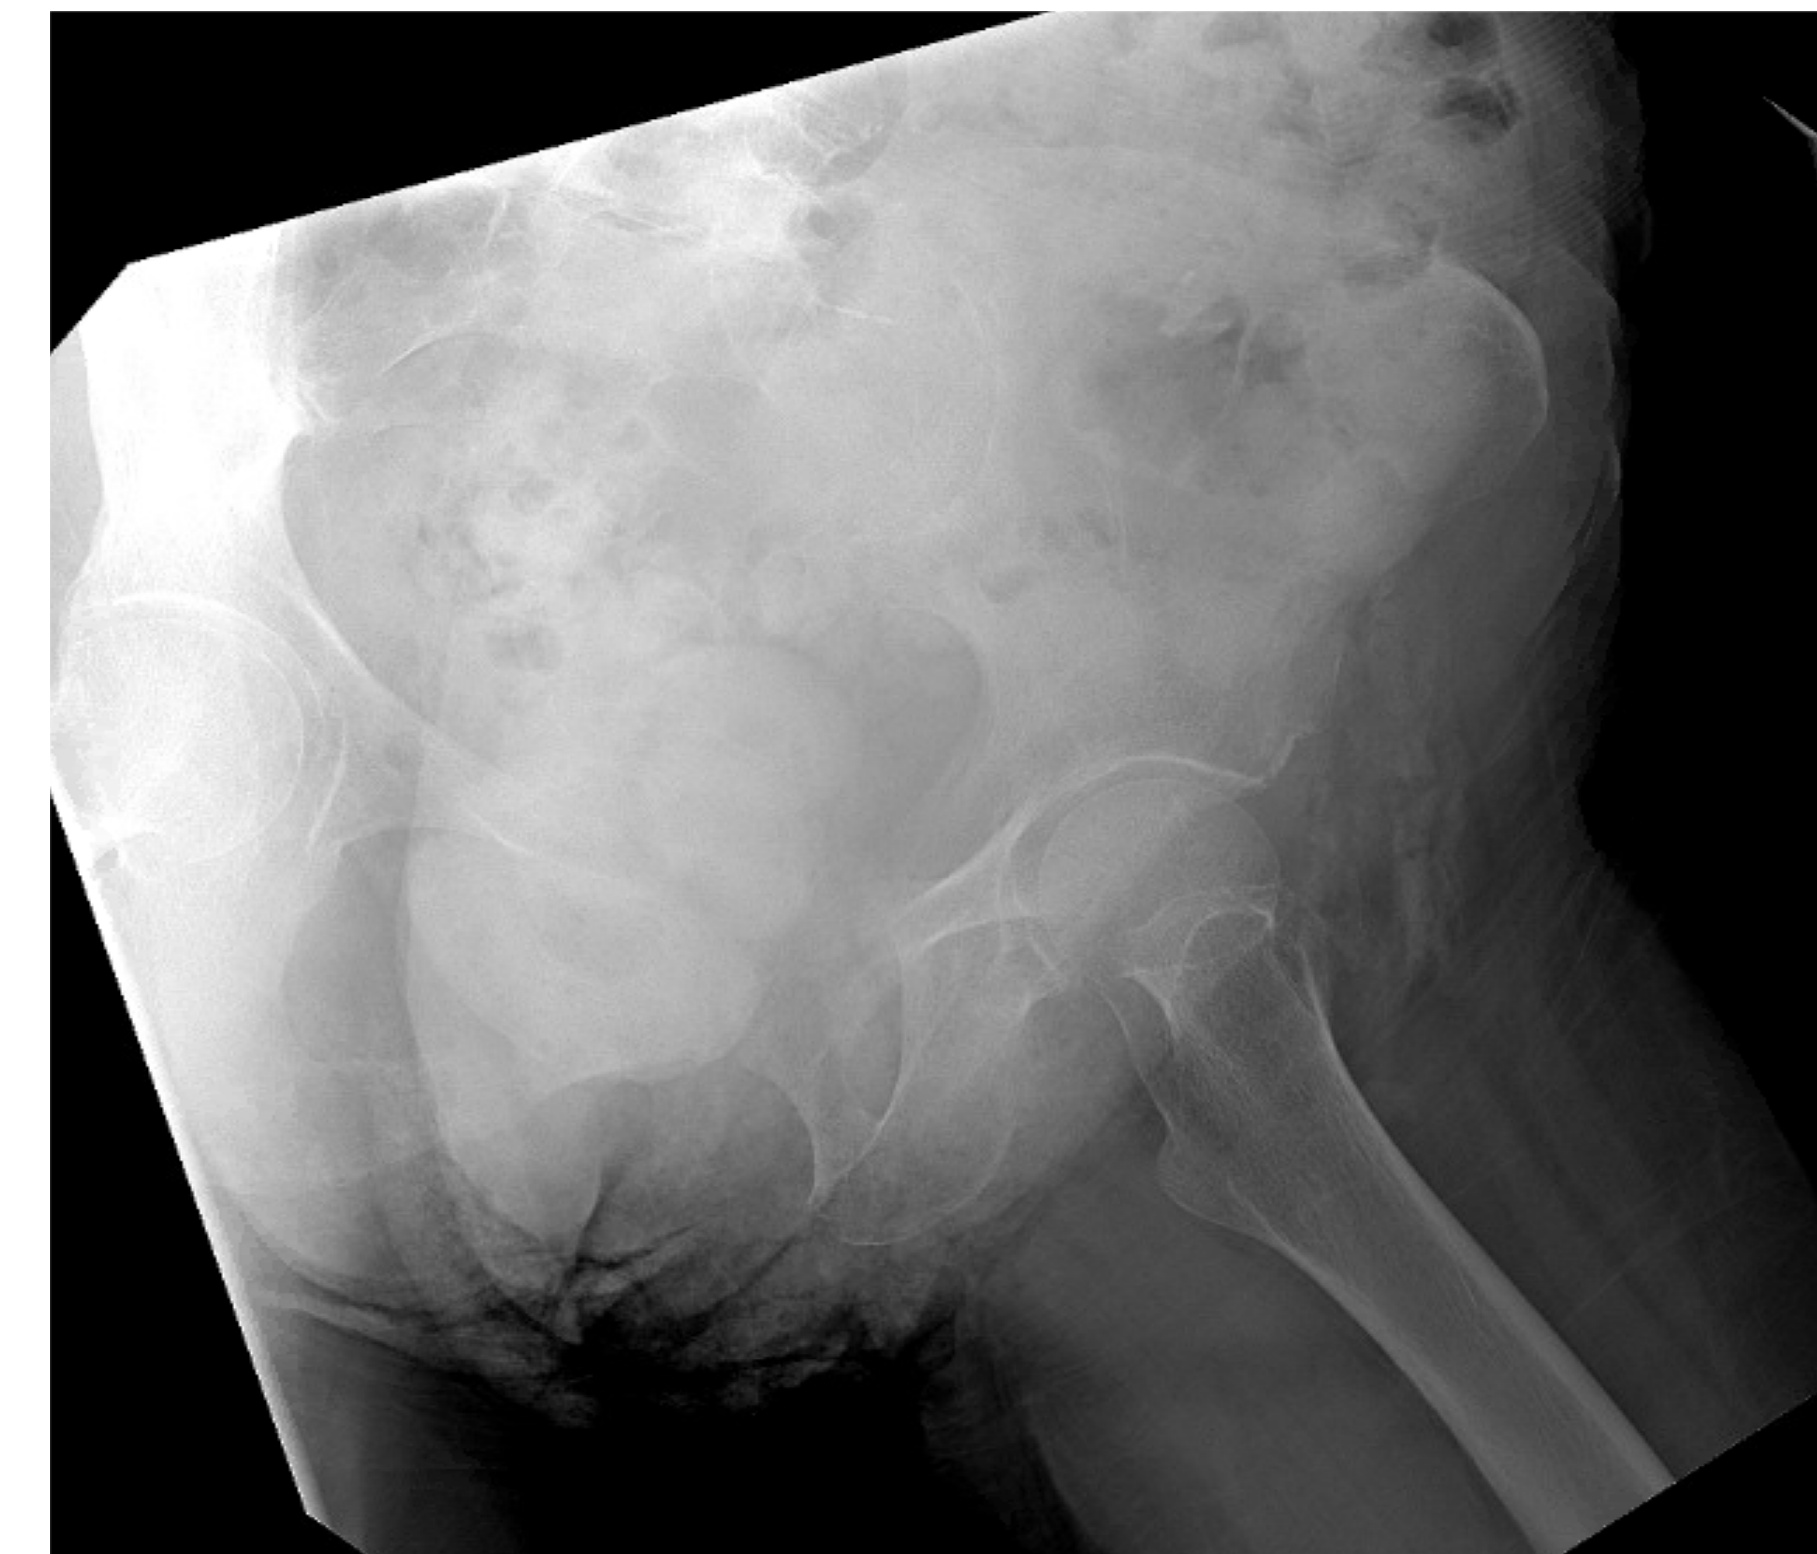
Left Pelvic radiograph of 75 year old woman displaying immature heterotopic ossification anterior to the left hip. The findings also include diffuse osteopenia, as well as mild left hip and sacroiliac joint osteophyte arthritis.
